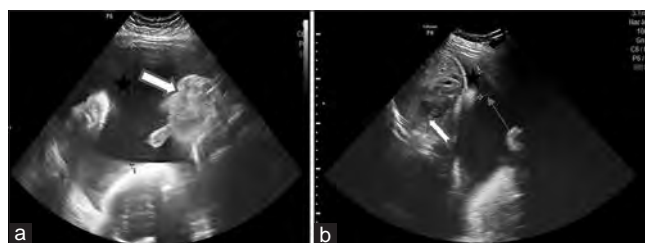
(a) Ultrasound image showing the recipient twin (block arrow) with increased fluid (star) around it. The deepest vertical pool was 12.3 cm. (b) The “stuck” donor twin (notched arrow) with minimal fluid (star) around it. The DVP was 1.8 cm. The thin amniotic membrane (thin arrow) is seen to separate the two fetuses
